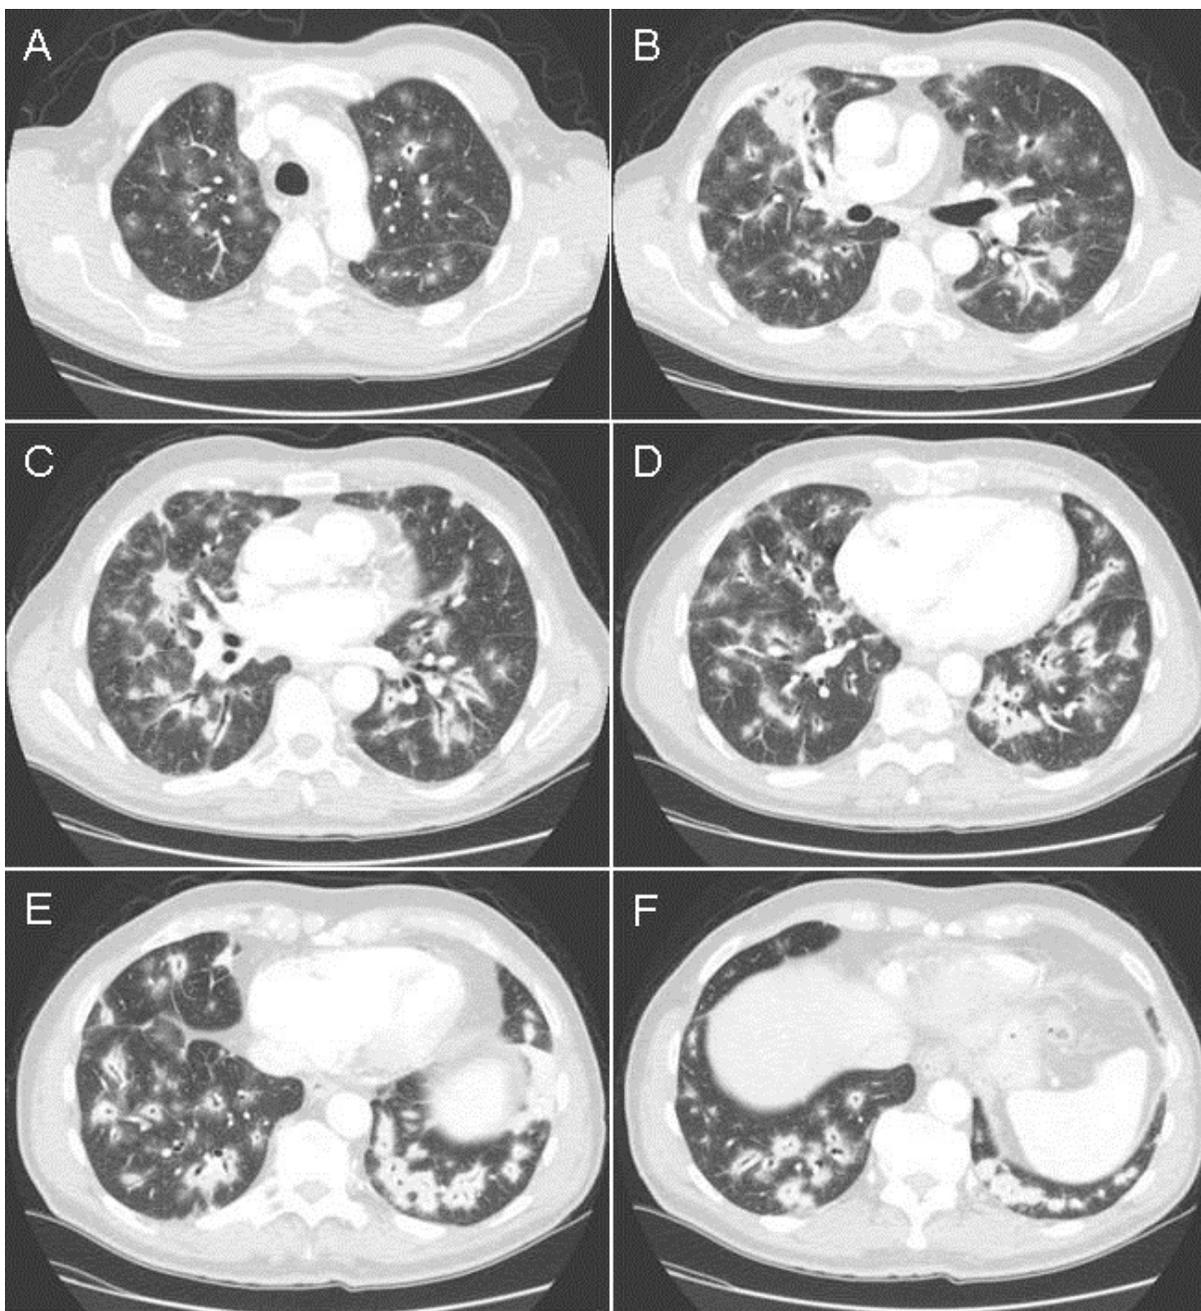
Representative images from contrast-enhanced thoracic CT scan in lung windows.
